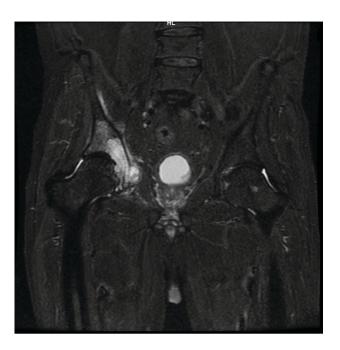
MRI aspect showing bone tumor involving the acetabulum with right iliac wing extension
